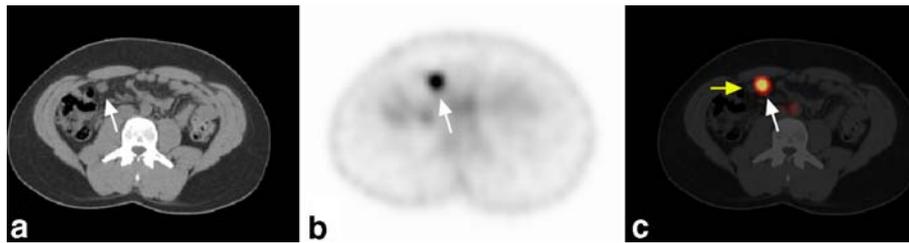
a Axial CT image demonstrated a blind-ending tubular structure in the right hemiabdomen (*arrow*). b Axial SPECT image obtained immediately following the acquisition of planar images demonstrated abnormal focal radiotracer activity in the right hemiabdomen (*arrow*). This did not seem to correspond to the planar activity that was likely within the urinary tract. c Axial fused SPECT/
